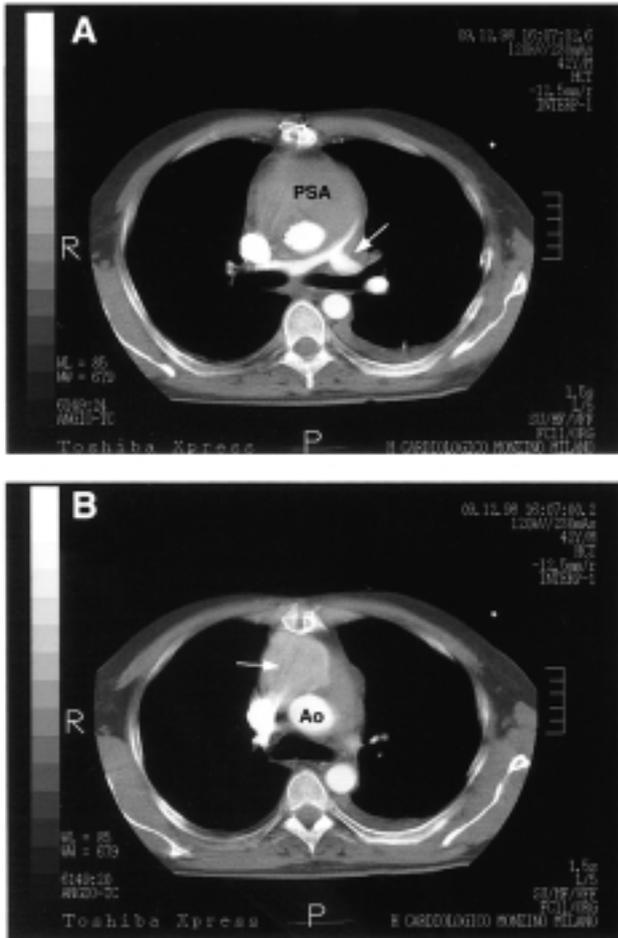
Preoperative spiral computed tomographic images showing the scanning planes at the level of the ascending aorta (Ao). A: the pulmonary artery and its main branches. The lumen is narrowed due to extrinsic compression (arrow). B: the contrast medium (arrow) causes faint opacification of the voluminous mediastinal mass around the Ao. PSA = pseudoaneurysm.
